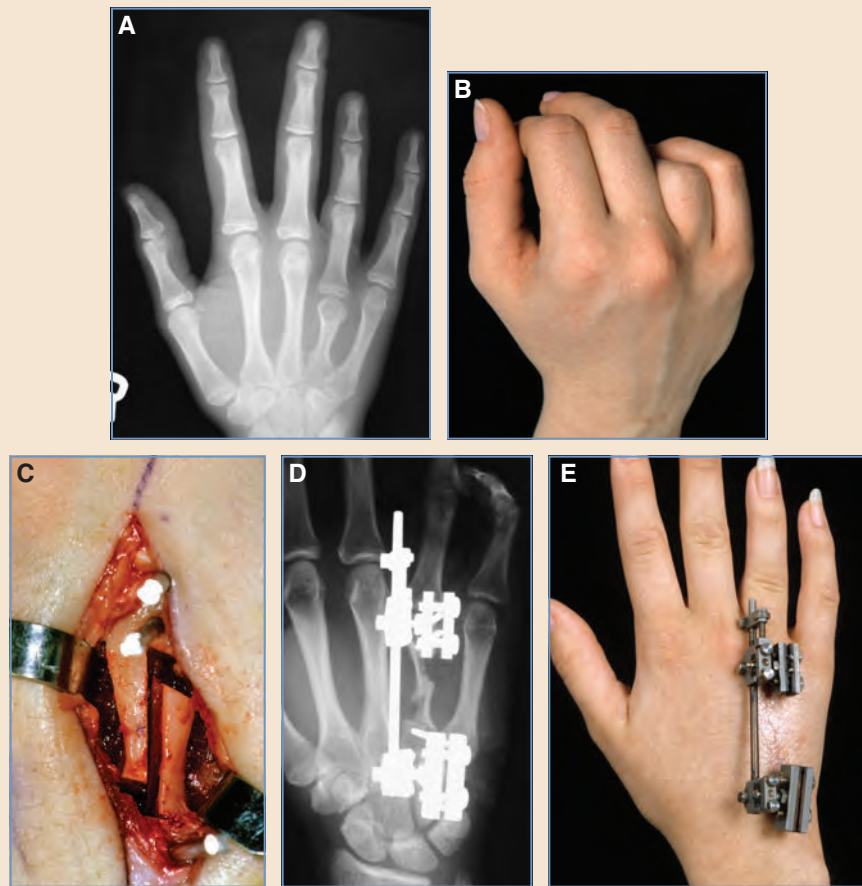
Distraction lengthening for brachymetacarpia of the right fourth metacarpal. A, Preoperative posteroanterior radiograph of the right hand. B, Preoperative view of the right hand. C, In this case, a step-cut osteotomy was made, through a dorsal longitudinal incision, to permit consolidation without bone grafting or callotaxis bone formation. Two sets of half-pins were used on either side of the osteotomy for fixation. D, Right hand posteroanterior radiograph during distraction lengthening. Some deformity into flexion occurred during distraction, necessitating realignment in the operating room. E, Right hand during distraction lengthening.
